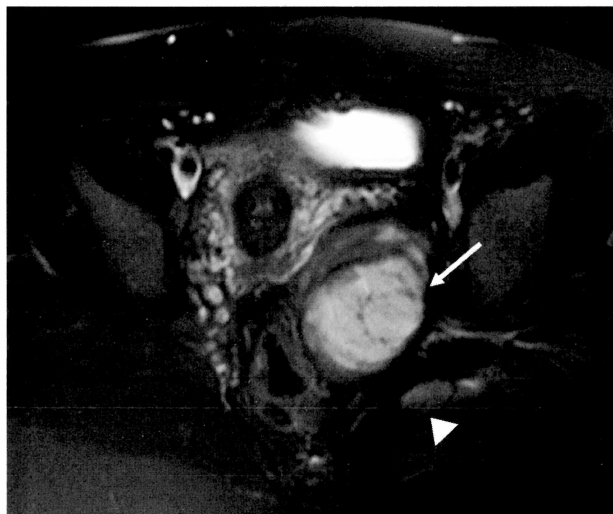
Axial T2-weighted image shows a large extraperitoneal, predominantly high signal intensity mass at the left paravaginal space (arrow). The mass, measuring 9.8 x 7.1 cm in size, extends to the obturator foramen. There is a second mass outside the pelvis in between the gluteal muscles. Two solid individual masses, the larger one at the left paravaginal space (arrow) and the smaller one (arrowhead) at the gluteus next to the sacral plexus, diffusely enhance after contrast administration.
